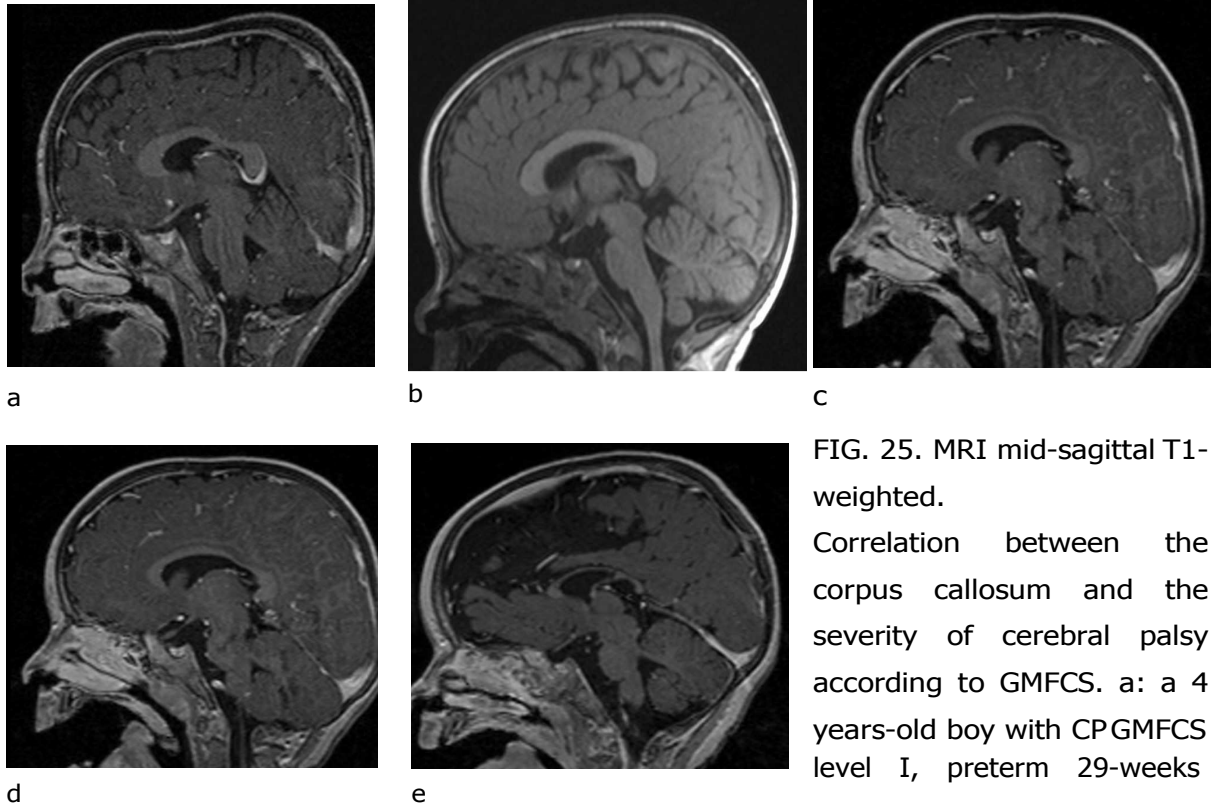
MRI mid-sagittal T1-weighted.
